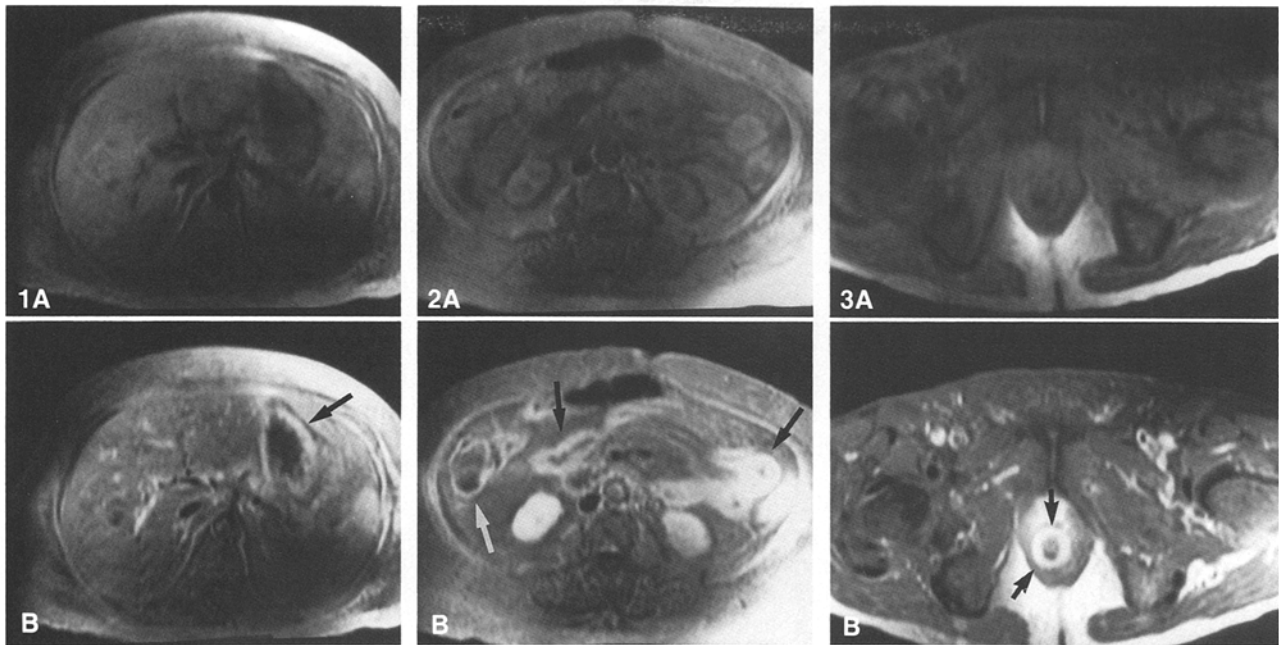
T1-weighted fat-suppressed images obtained before (A) and following (B) intravenous gadopentetate dimeglumine injection. Diffuse mural enhancement is demonstrated throughout the stomach which is mildly distended by fluid (arrow).
